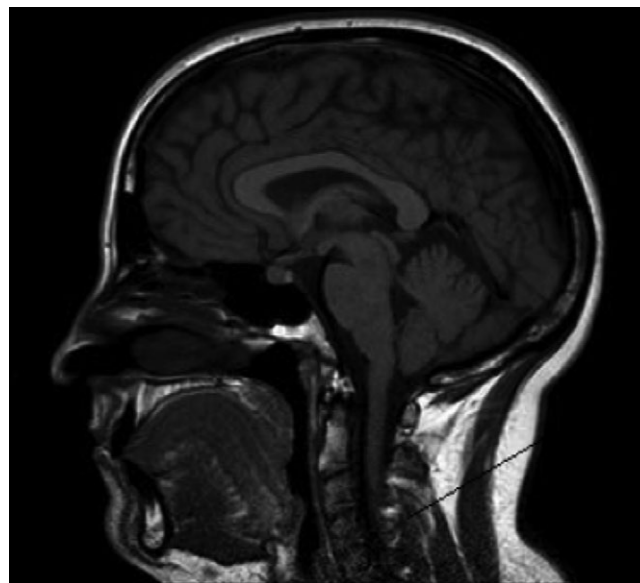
Sagittal cranial MRI at 34 years 6 months, confirming previous tonsil tips position.
